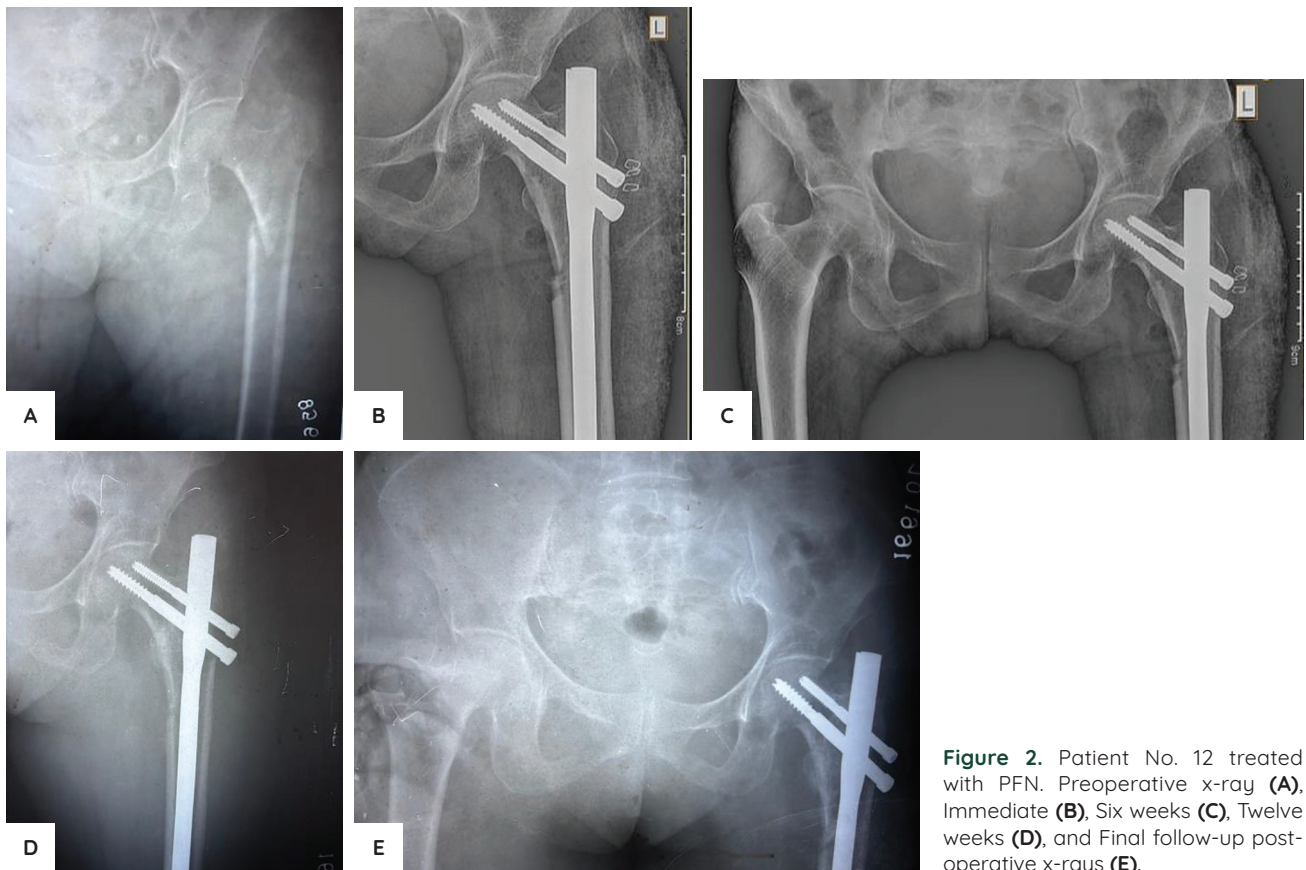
Patient No. 12 treated with PFN. Preoperative x-ray (A), Immediate (B), Six weeks (C), Twelve weeks (D), and Final follow-up post-operative x-rays (E).
